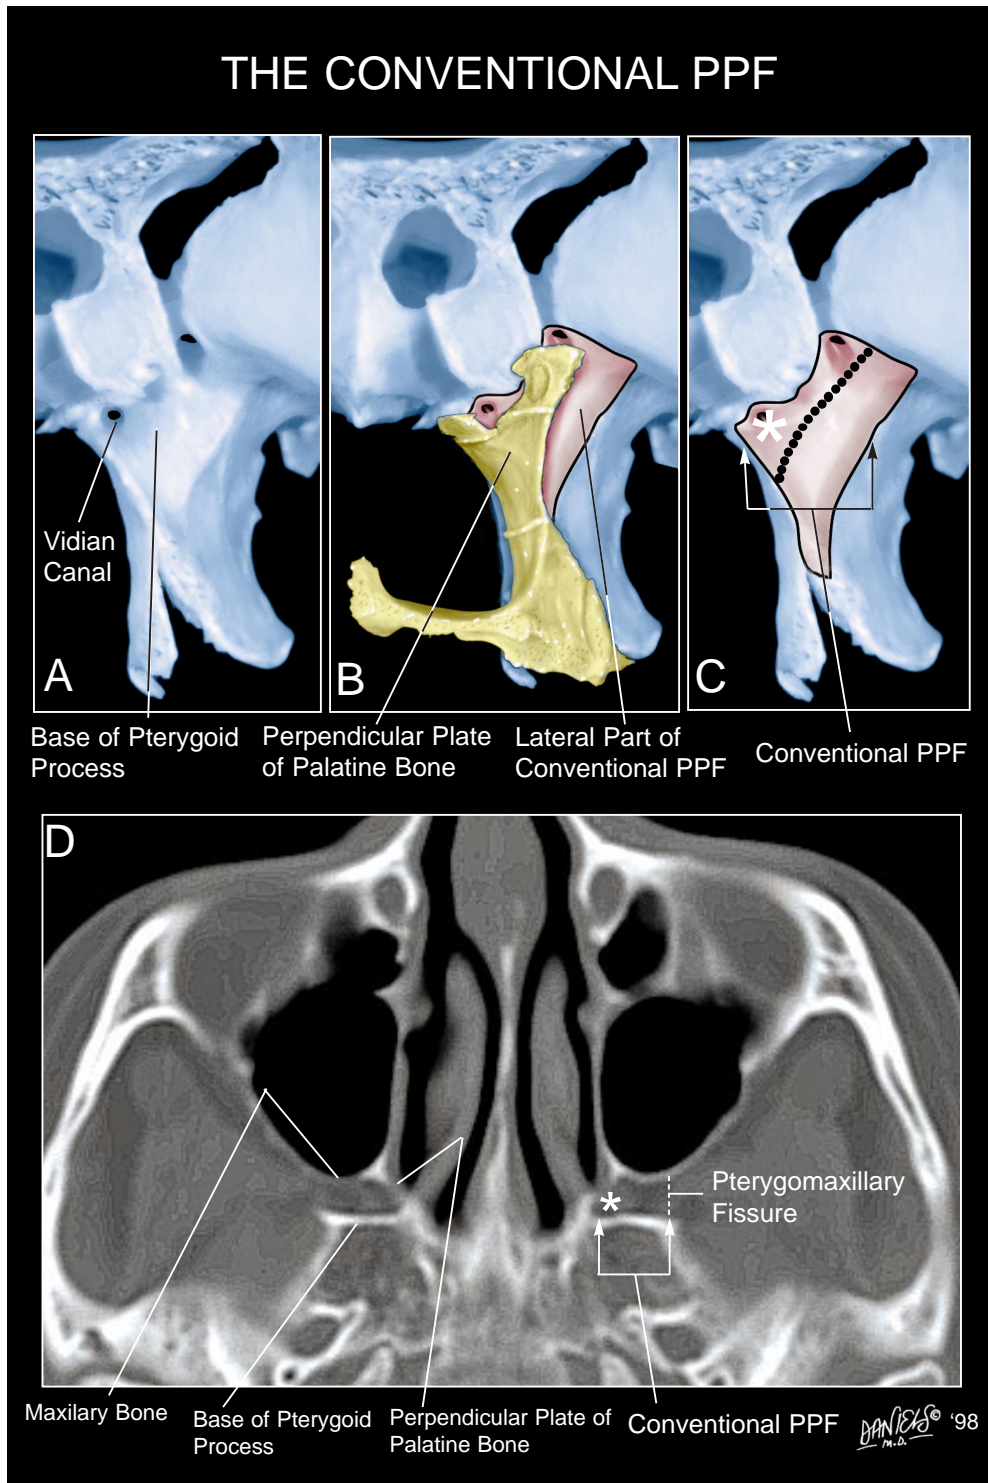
Frontal views (A-C) and axial CT scan (D) through the pterygoid process.
